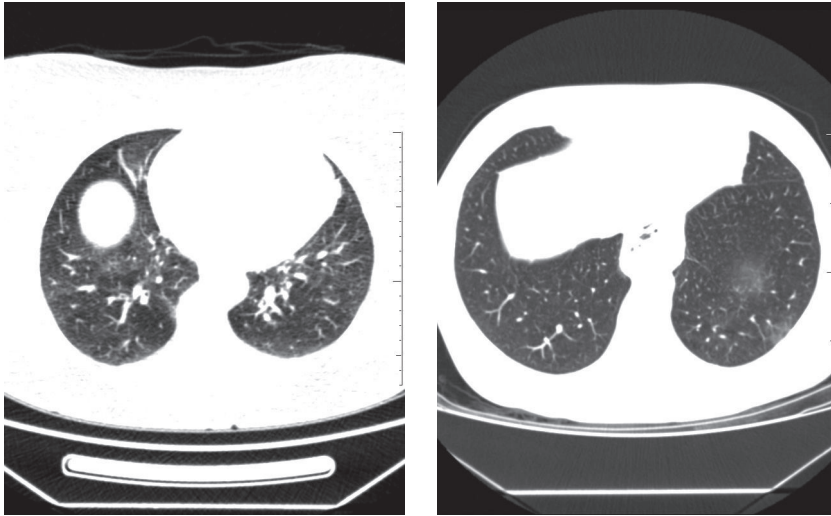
Axial chest CT scans showing areas of ground-glass attenuation in the left lower lobe.
